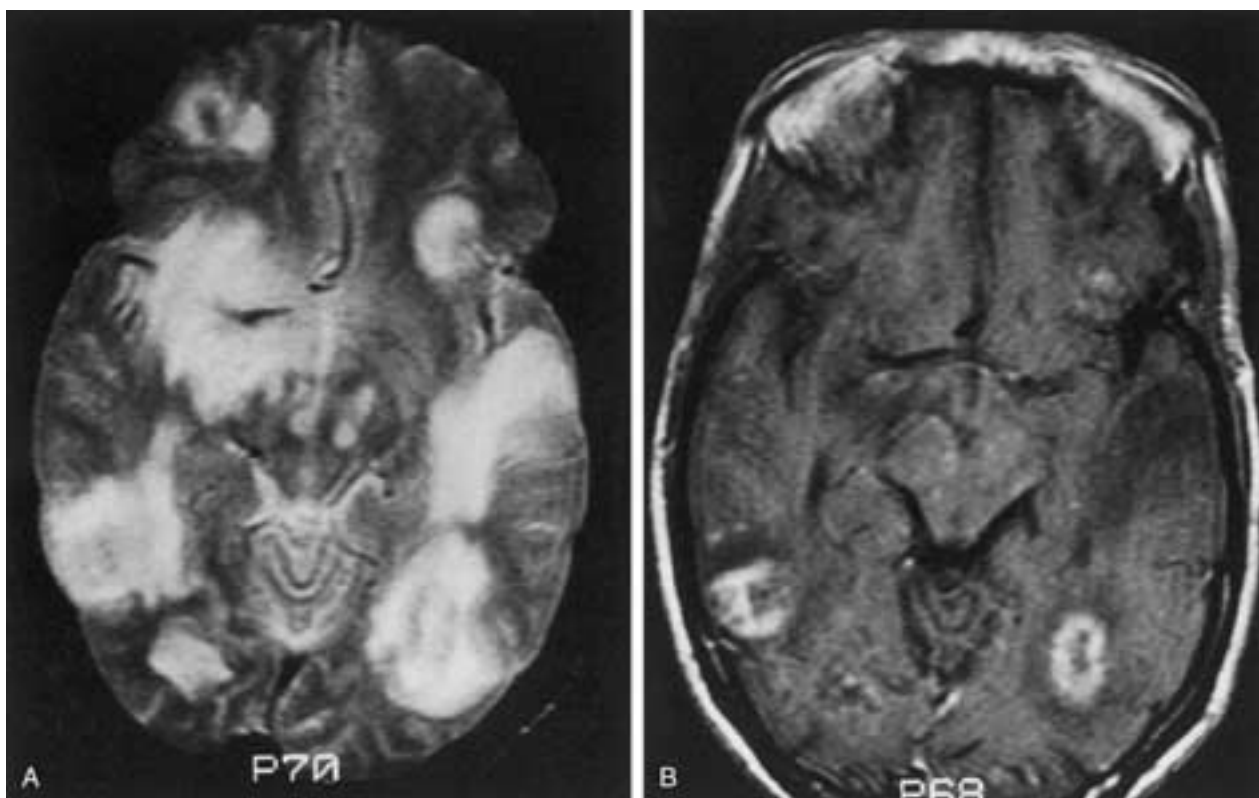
Toxoplasmosis abscesses in an HIV-positive 30-year-old male. A, Axial T2-weighted MR image shows multiple high signal intensity masses at the gray matter–white matter junctions and within the brainstem. B, Axial T1-weighted MR image after gadolinium injection shows enhancing masses with central necrosis.
